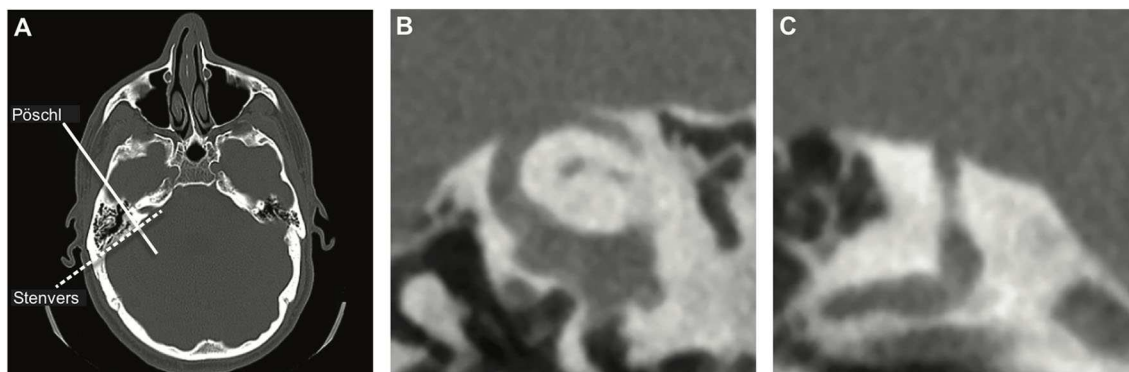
CT images. (A) Axial view of the head indicating reformatting planes parallel (Pöschl—solid line) and perpendicular (Stenvers—dashed line) to the plane of the superior semicircular canal (SSC). (B) Pöschl view and (C) Stenvers view of a dehiscence of the SSC. The normal bony covering of the SSC is clearly absent in both views.
